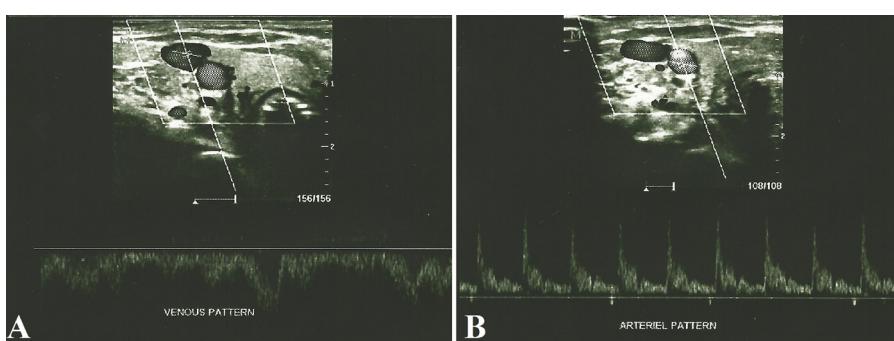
A: Venous flow pattern (right internal juguler vein) on a Doppler assessment. B: Arterial flow pattern (right common carotid artery) on a Doppler assessment
